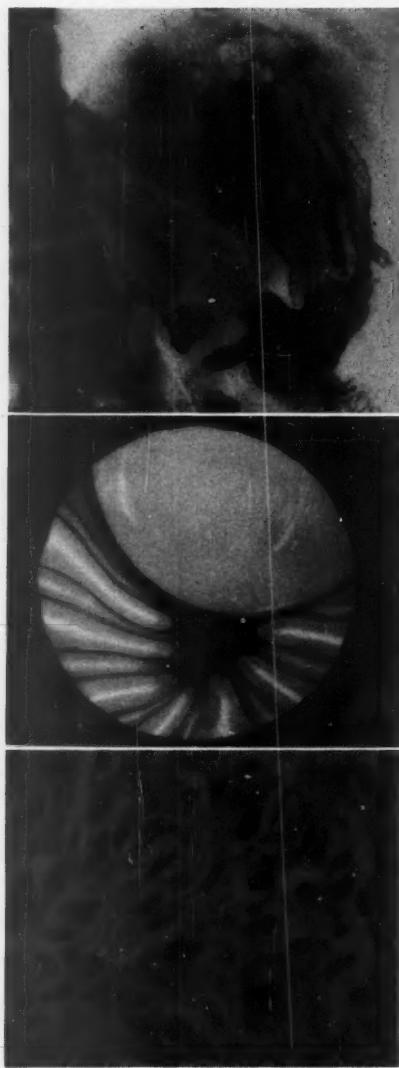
(Top). X-ray revealed no evidence of a golf-ball size tumor in the fundus of the stomach.
